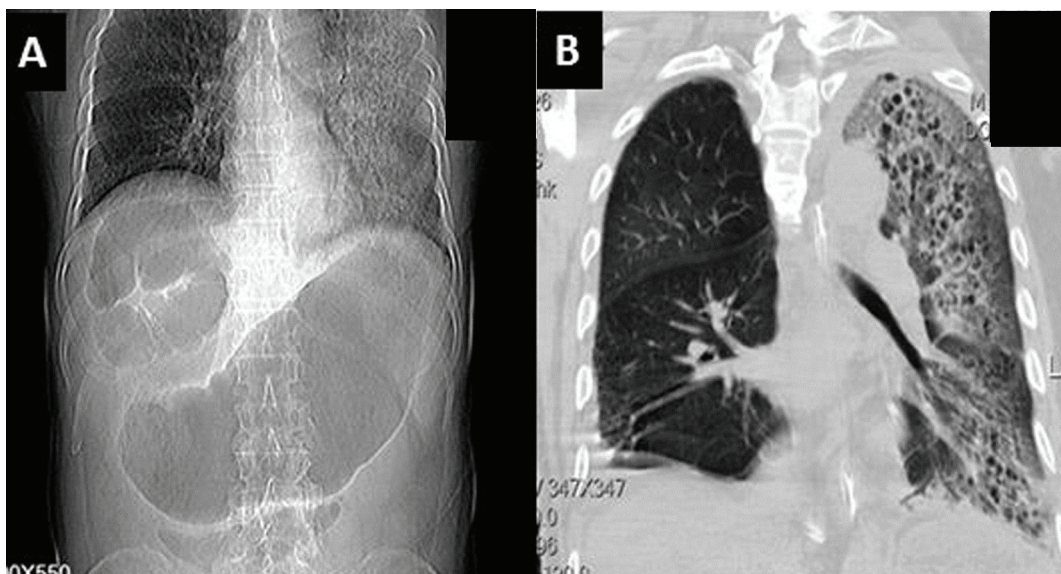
(A) Anteroposterior plain abdomen radiography shows a distended gastric bulb, compatible with gastric outlet obstruction. (B) Computed tomography scan of the lung shows multiple cystic lesions within dependent parts of the consolidated left lung.
